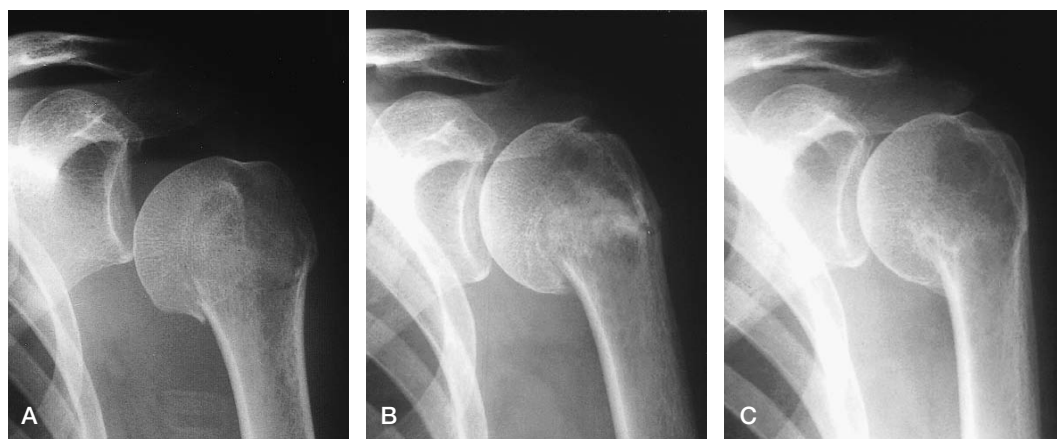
The antero-posterior radiographs of a 54-year-old woman who presented with an A2.2 impacted varus fracture (A). This was treated non-operatively but at 6 weeks there was evidence of increasing angulation (B) which was unchanged at 1 year (C). The final Neer score was 94.
